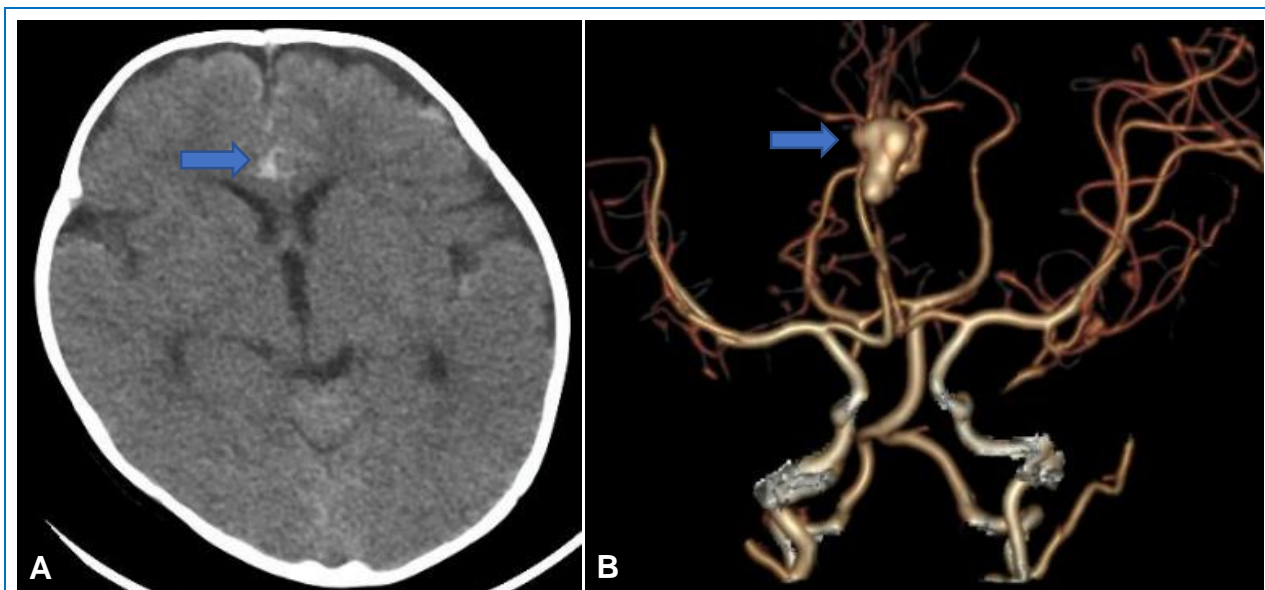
(A) Brain CT without contrast in axial section showing subarachnoid hemorrhage predominantly subcortical at the interhemispheric bifrontal level, predominantly on the right side (blue arrow). (B) 3D reconstruction of cerebral Angiotomography, showing dysplastic aneurysm, at the level of the marginal callus arteries (blue arrow)
